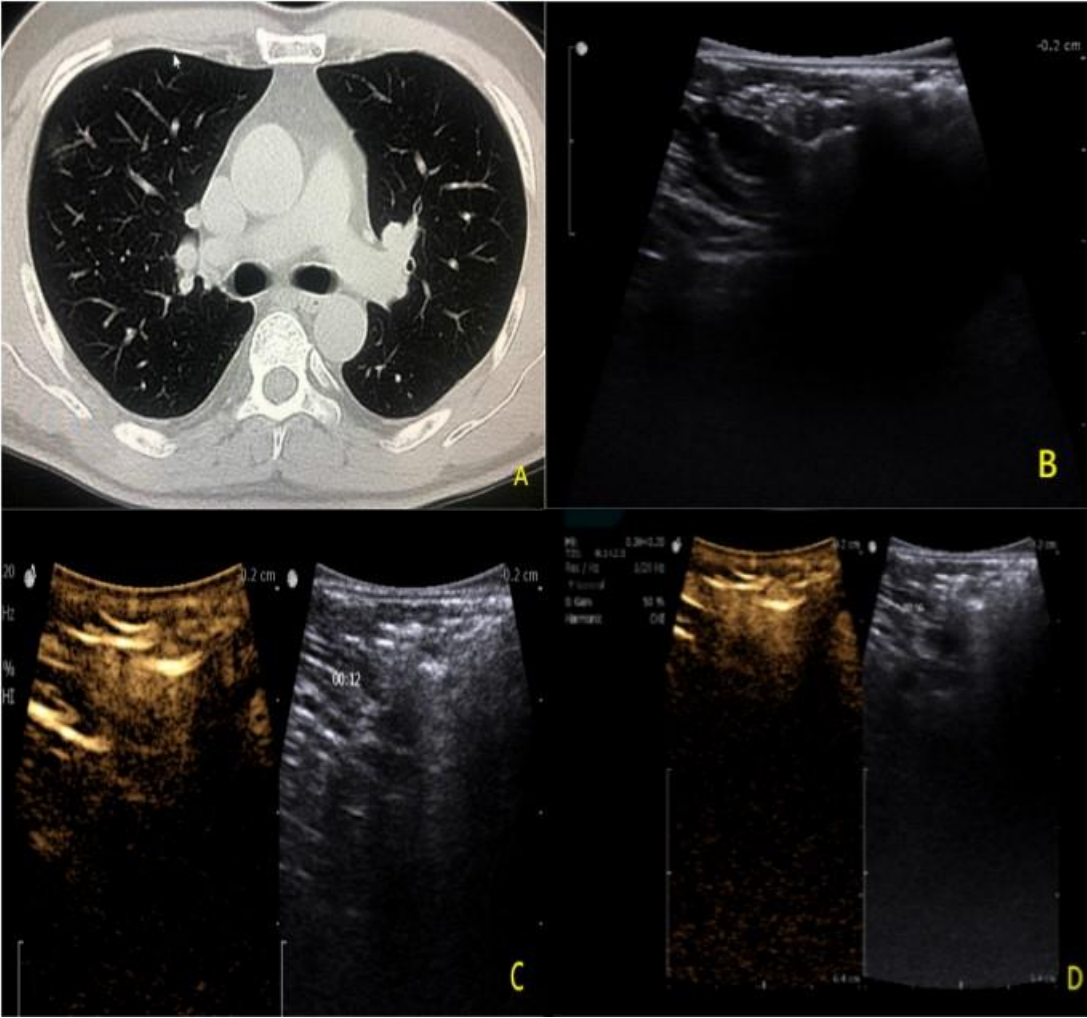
Image of preoperative HRCT, intraoperative two-dimensional ultrasonic and contrast-enhanced ultrasonic in patients with pGGN. A. Before operation, HRCT
